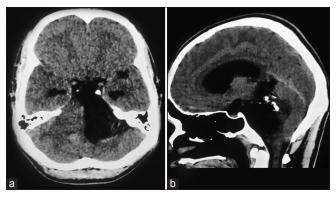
(a and b) Preoperative computed tomography scan of the brain suggestive of a hypodense lesion in the left cerebellopontine angle with peripheral calcifications.
